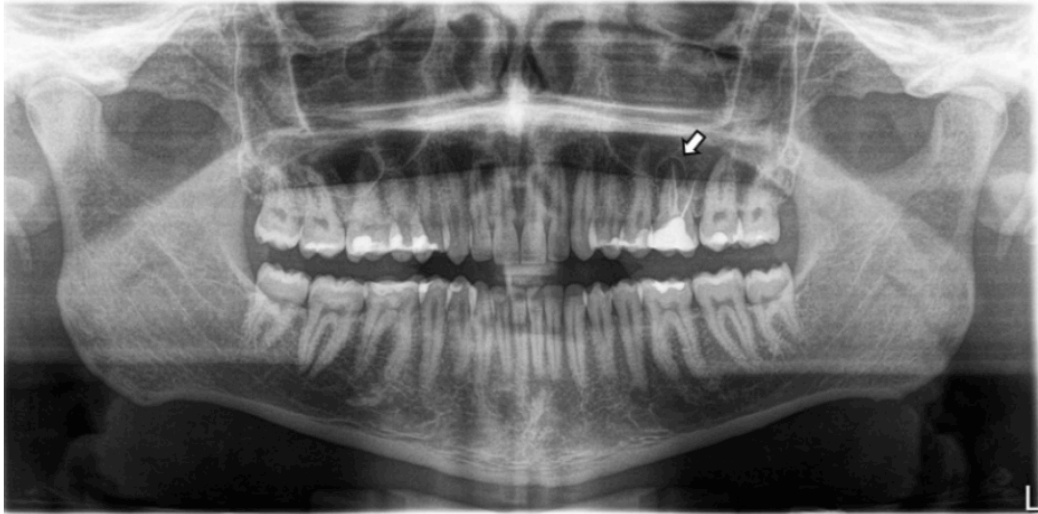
Panoramic radiograph with a white arrow indicating a periapical lesion in tooth 26.
